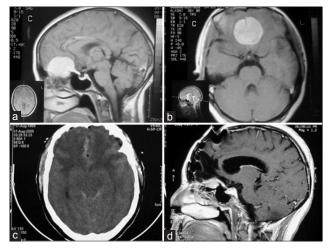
(a and b) Pre-operative sagittal and axial T1-weighted MRI with gadolinium contrast injection showing the homogenous enhancement by an olfactory groove meningioma. (c) Immediate post-operative brain CT shows tumor removal and vasogenic brain edema. (d) Post-operative sagittal T1-weighted MRI with gadolinium contrast reveals near total resection of the tumor
